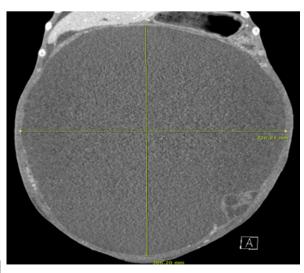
Abdomen-pelvis CT. Large cystic mass with mural multiseptated cystic portion in the abdominopelvic cavity
